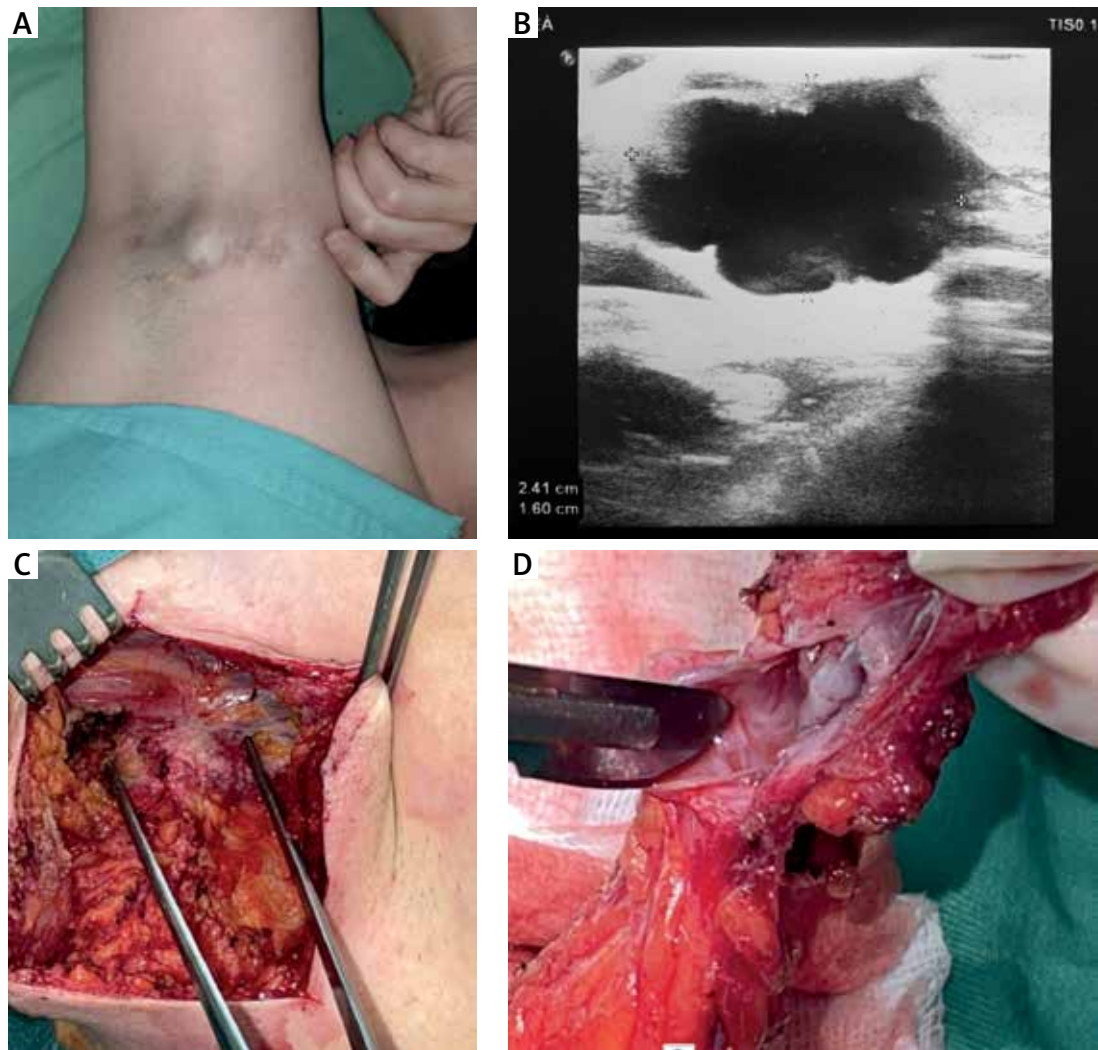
A – Clinical examination showing lump in the right axilla; B – Ultrasonography image; C – Intra-operative finding of the tumour; D – Cystic structure of the tumour
